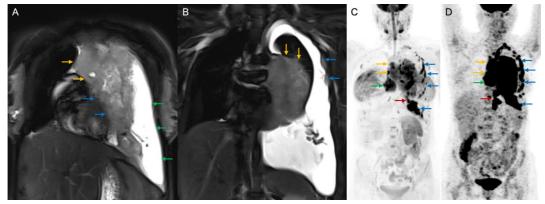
Stage IV on both WB-MRI and PET-CT. A. Coronal STIR image showing large heterogeneously hyperintense mediastinal mass (yellow arrows) with few cystic components within. The mass can be seen infiltrating into the pericardium inferiorly (blue arrow). Associated pleural effusion (green arrows) is also seen. B. The mass is seen infiltrating into the left lung (yellow arrows). A few hyperintense pleural deposits (blue arrows) are also seen along the left lateral chest wall. C. Coronal MIP DIW image showing diffusion restricting large mediastinal mass. Multiple diffusion-restricting pleural deposits are seen along the left lateral chest wall and diaphragmatic pleura (blue arrows). Diffusion-restricting lymph nodes are also seen in the para-cardiac region (green arrow) and para-oesophagal (red arrow). D. Coronal MIP PET image showing FDG avid large mediastinal mass. Multiple FDG avid pleural deposits are seen along the left lateral cheat wall and para-oesophagal (red arrow). FDG avid lymph nodes are also seen in the para-cardiac region (green arrow) and para-oesophagal (red arrow). D. Coronal MIP PET image showing FDG avid large mediastinal mass. Multiple FDG avid pleural deposits are seen along the left lateral cheat wall and para-oesophagal (red arrow). FDG avid lymph nodes are also seen in the para-cardiac region (green arrow) and para-oesophagal (red arrow). D. Coronal MIP PET image showing FDG avid large mediastinal mass. Multiple FDG avid pleural deposits are seen along the left lateral cheat wall and diaphragmatic pleura (blue arrows). FDG avid lymph nodes are also seen in the para-oesophagal (red arrow) and para-oesophagal (red arrow) and para-oesophagal (red arrow) and para-oesophagal (red arrow).
